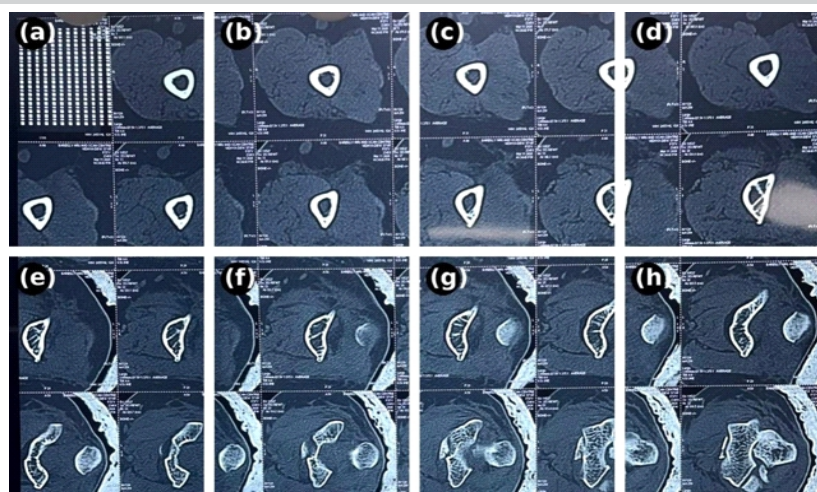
Computed tomography reconstructions of the left elbow confirming all four components of the “terrible tetrad” from multiple projections.
